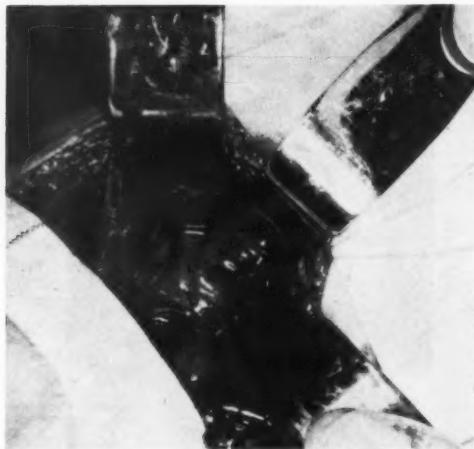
Bladder mucosal saccule at surgery. The right uretero-vesical junction visualized with a ureteral catheter passing from the interior of the bladder into the ureter. Immediately adjacent to it is the "dimple" or defect in the musculature of the bladder that allows the mucosa in this area to herniate and produce the roentgen appearance of a saccule. (Surgical photograph, courtesy of Dr. Robert Osborne.)
